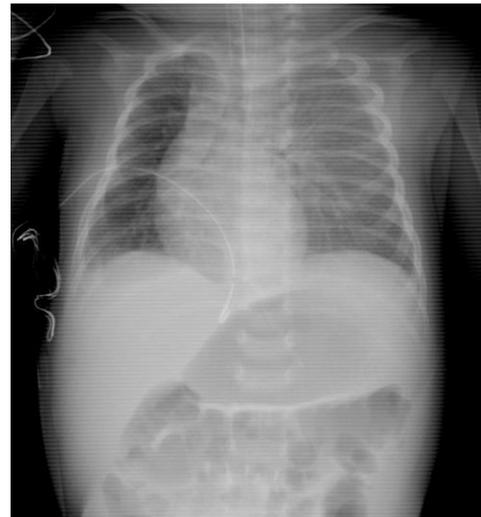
Chest radiograph showing right side pleural effusion and pneumothorax
